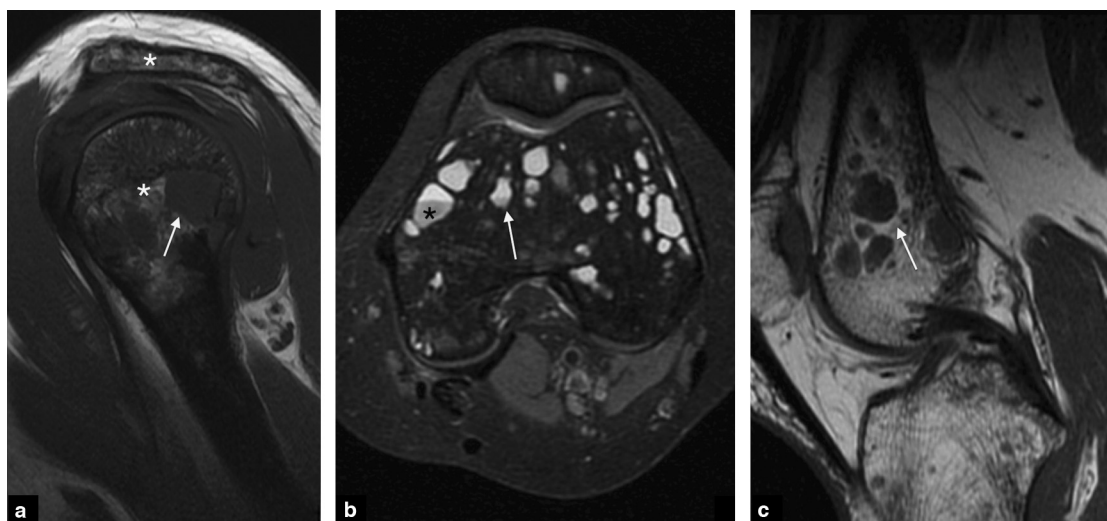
a: T1 post-gadolinium weighted images showing multilocular lytic lesions of the humerus; b: T2-Fat Sat weighted images showing multilocular lytic lesions of the knee; c: T1-weighted images showing multilocular lytic lesions of the knee. The white arrows and the white asterisks show the location of the cystic lesions.
